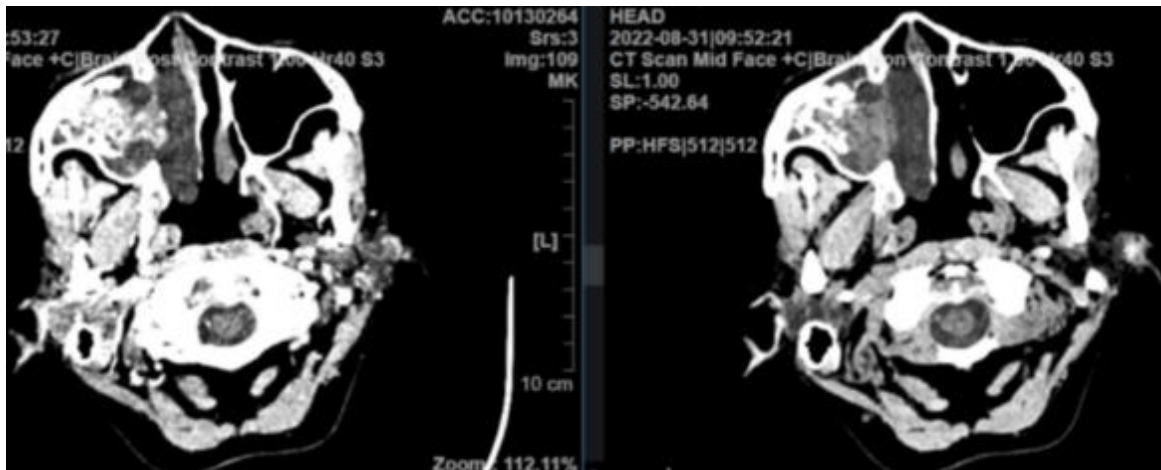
Nasal and paranasal sinuses CT scan with contrast
